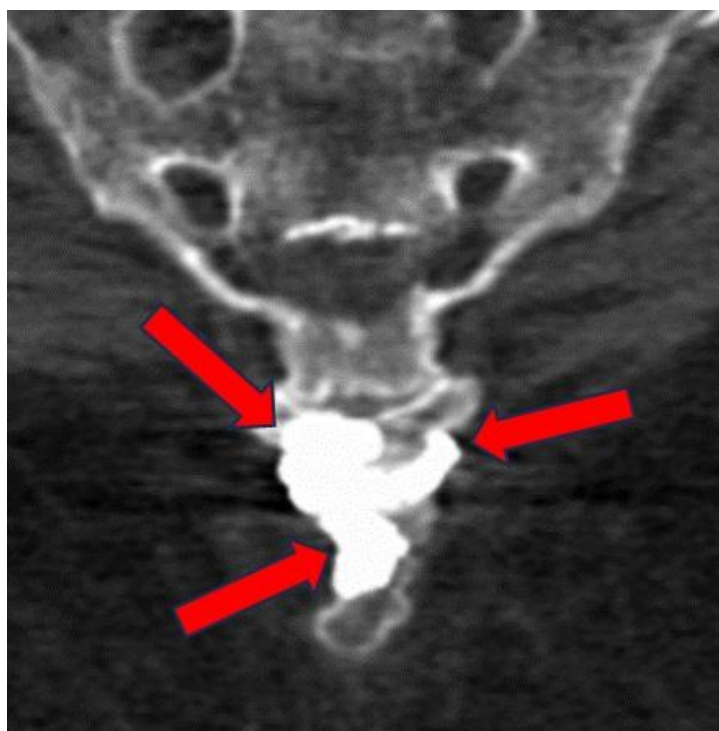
CT spiral, coronal reconstruction to control the distribution of medical cement (arrows).*
